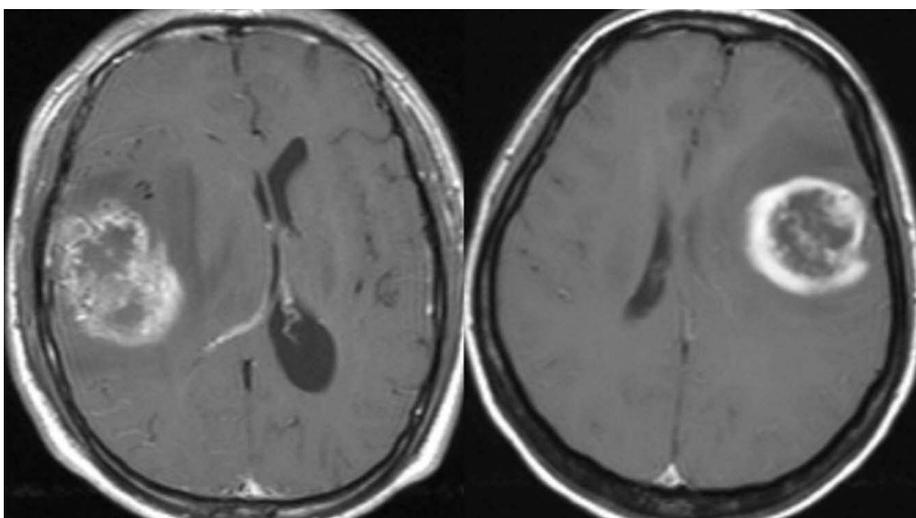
The axial Gd-enhanced T1-weighted MR images obtained from two patients with non cystic GBMs. The non cystic GBM shows an irregular shape, a poor interface and an enhanced thick and uneven wall on the Gd-enhanced T1-weighted MR images.
